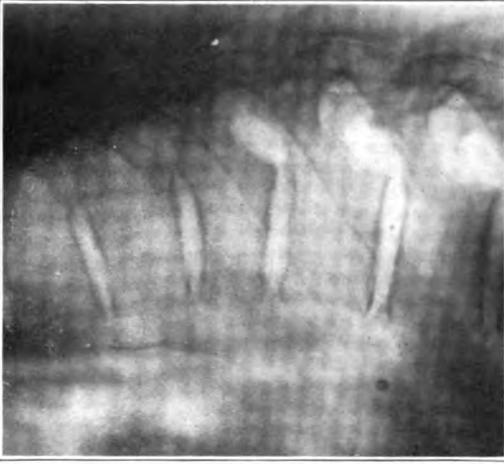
X-ray of epileptic, Case No. 115. Major fracture—D6. Minor fracture—D7.
